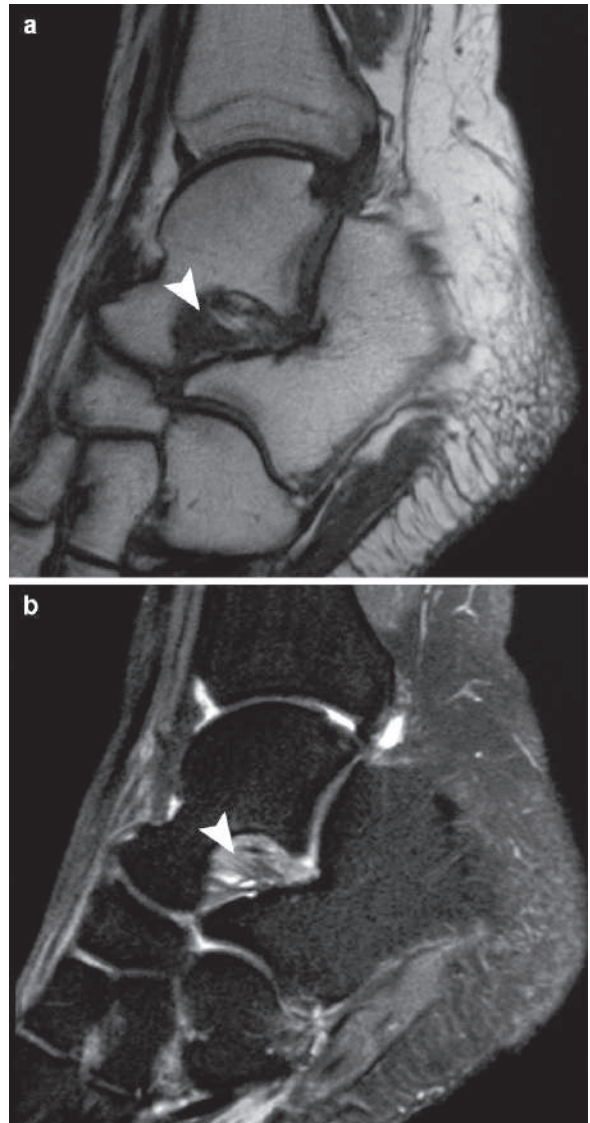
Sagittal T1W (a) and STIR (b) ankle MRI of a patient with chronic sinus tarsi syndrome show mild hyperintense signal within the sinus tarsi with disruption of the interosseus ligament (arrowhead)
